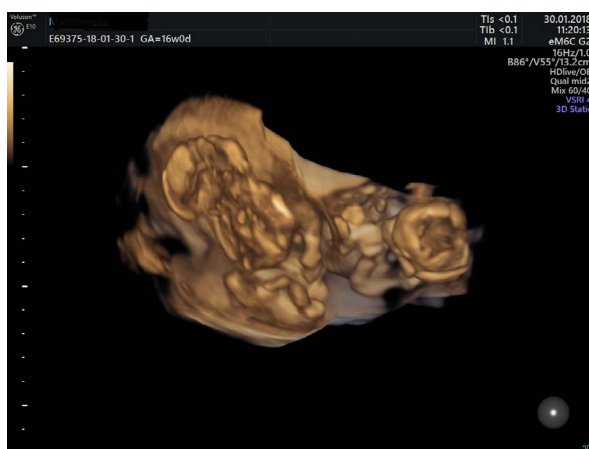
Ultrasongraphic 3D reconstruction of conjoined twins and third fetus in 16th week of gestation
